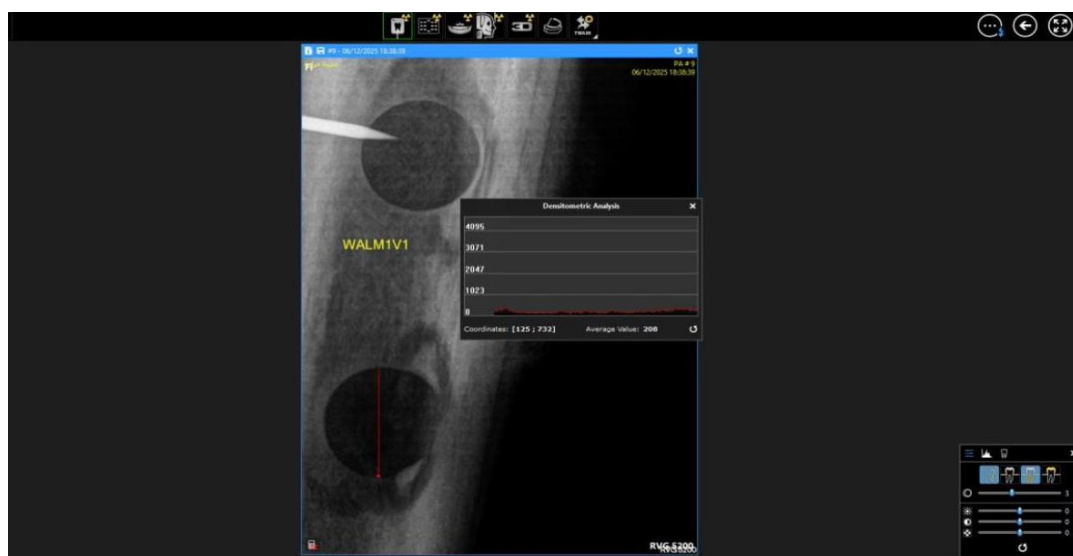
Radiographic screenshot labelled WALM1V1, showing darker circular defect areas and a low average densitometric value in the selected field.
